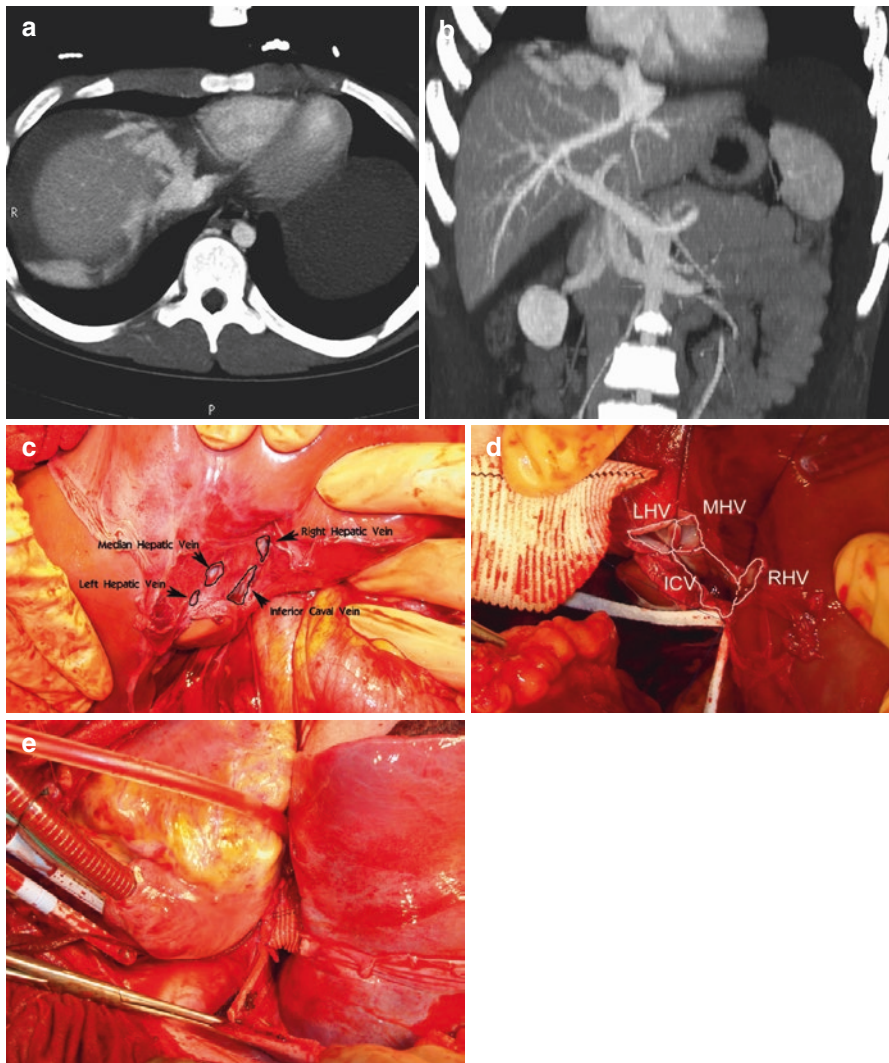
High-velocity ski accident in a 14-year-old man. Transport of hemodynamically stable, hypothermic (33.3 °C) patient was made to trauma center; intubation on arrival motivated by extreme agitation. CT scan showed blood extravasation at the level of the suprahepatic IVC and the absence of associated injuries (a, b). Sternotomy, CBP, and laparotomy were successively done and confirmed complete disjunction of the vena cava and of the three suprahepatic veins (c). After complete liver vascular exclusion, the suprahepatic veins were anastomosed together and then on a 30 mm diameter Dacron graft (Hemashield®) (d), the graft was then sutured to the subdiaphragmatic IVC (e)
